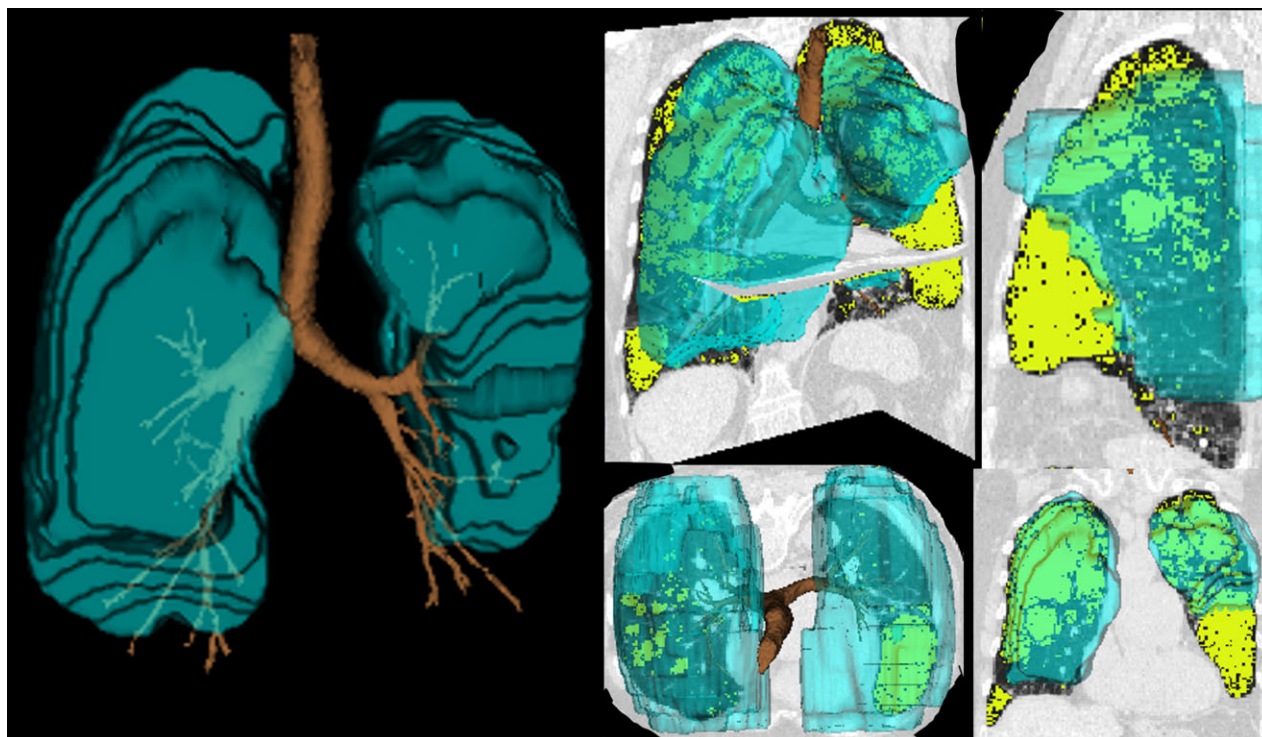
Spatial relationship between ^3He MRI ventilation defects and CT of a subject with airways disease dominant COPD. Co-registration of ^3He MRI static ventilation (shown in blue) and CT (shown in greyscale) with airway rendering (shown in yellow). A lower right lobe ventilation defect was identified and is shown in the coronal, axial and sagittal views.
